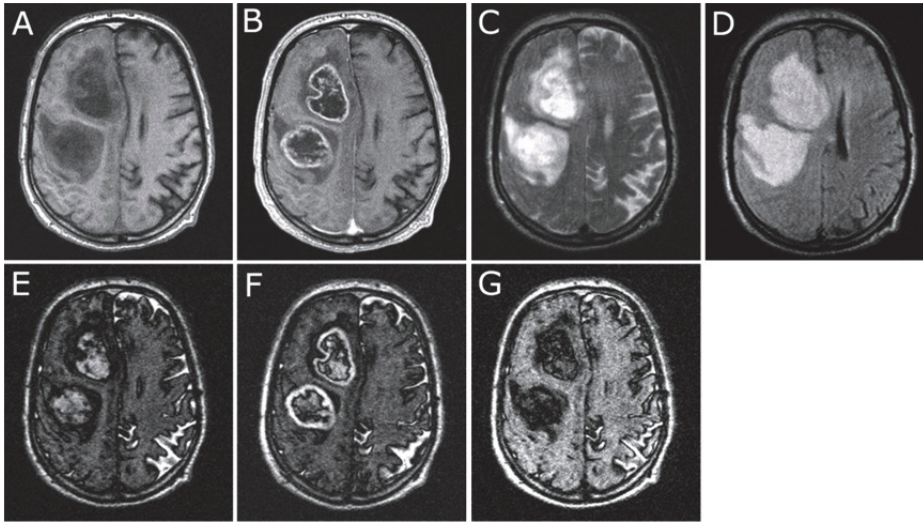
(Case 3). IR sequence with TI of 600 ms without i.v. contrast medium could in this case show the delineation of tumors from the surrounding edema as well as did  $T_1$  with contrast medium. Two large tumors in the right frontal lobe (glioblastoma multiforme, GBM) are shown in  $T_1$  weighted sequences without (A) and with (B) contrast enhancement. The tumors are well delineated from the surrounding edema. In  $T_2$  (C) and FLAIR (D) the edema is visible as high signal intensity, but the tumors cannot be demarcated. The IR sequence with TI of 600 ms both without (E) and with (F) contrast enhancement shows the delineation of the tumors from the edema. It should be noted that even in the non-enhanced IR TI 600 ms sequence the tumors are approximately of the same size as in the contrast enhanced  $T_1$  sequence (B). The same TI cannot be applied to all patients, which is demonstrated when an IR sequence with TI of 800 ms was evaluated (G). In this case both the tumors and the edema were suppressed.
